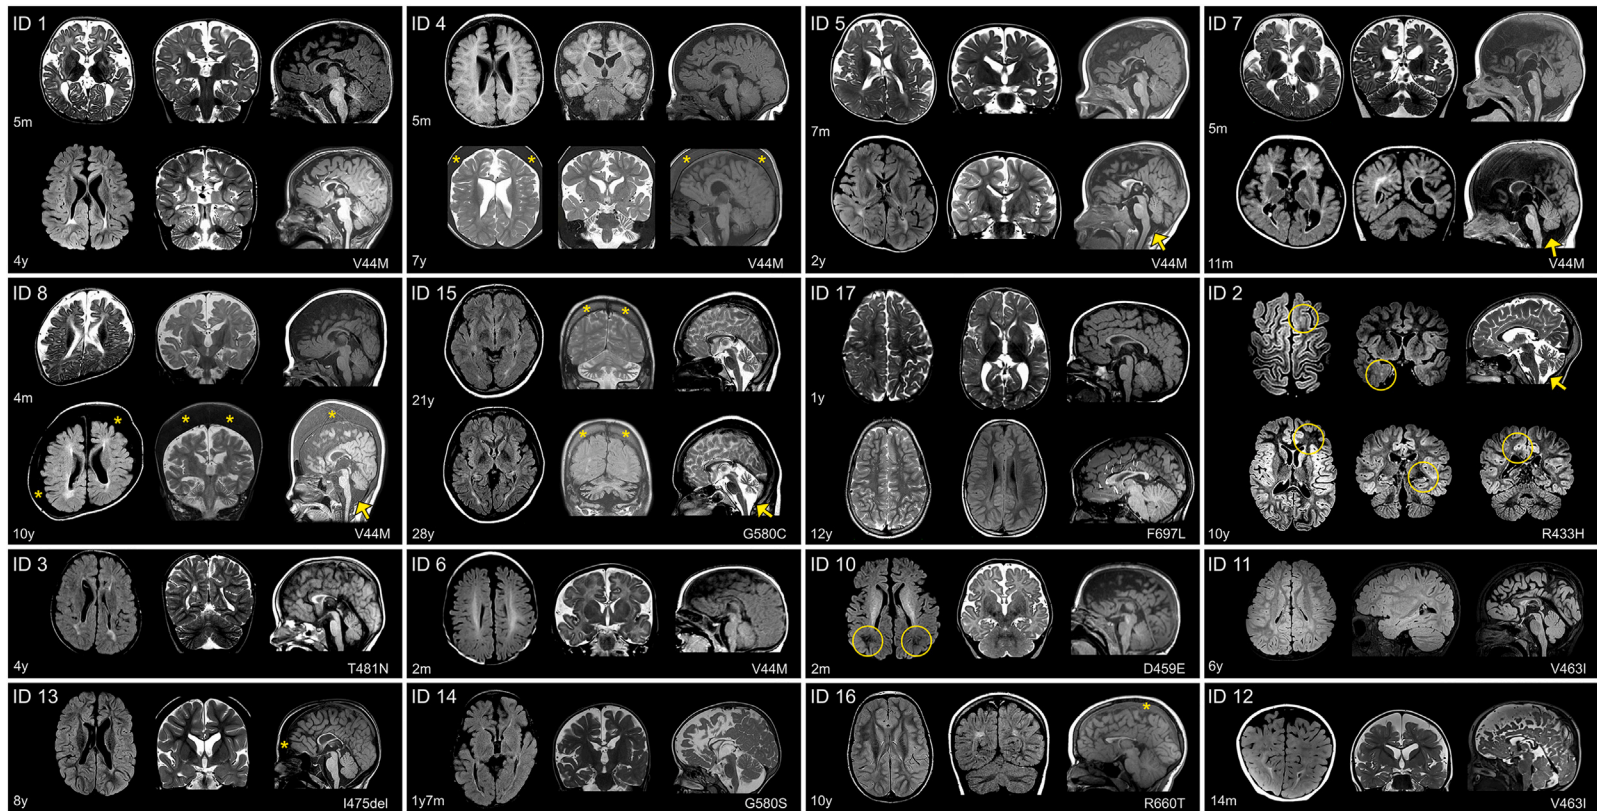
Brain MRI in 16 individuals with *TMEM63B* pathogenic variants
